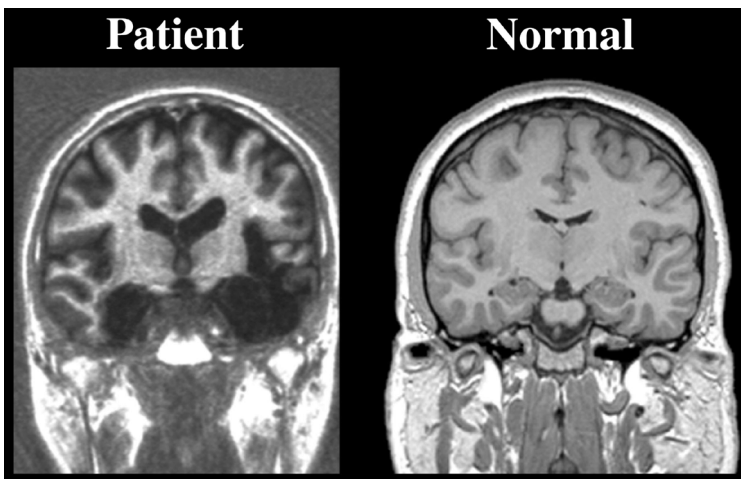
CW's MRI scan from 1991 compared with a non-brain damaged age-matched control.
